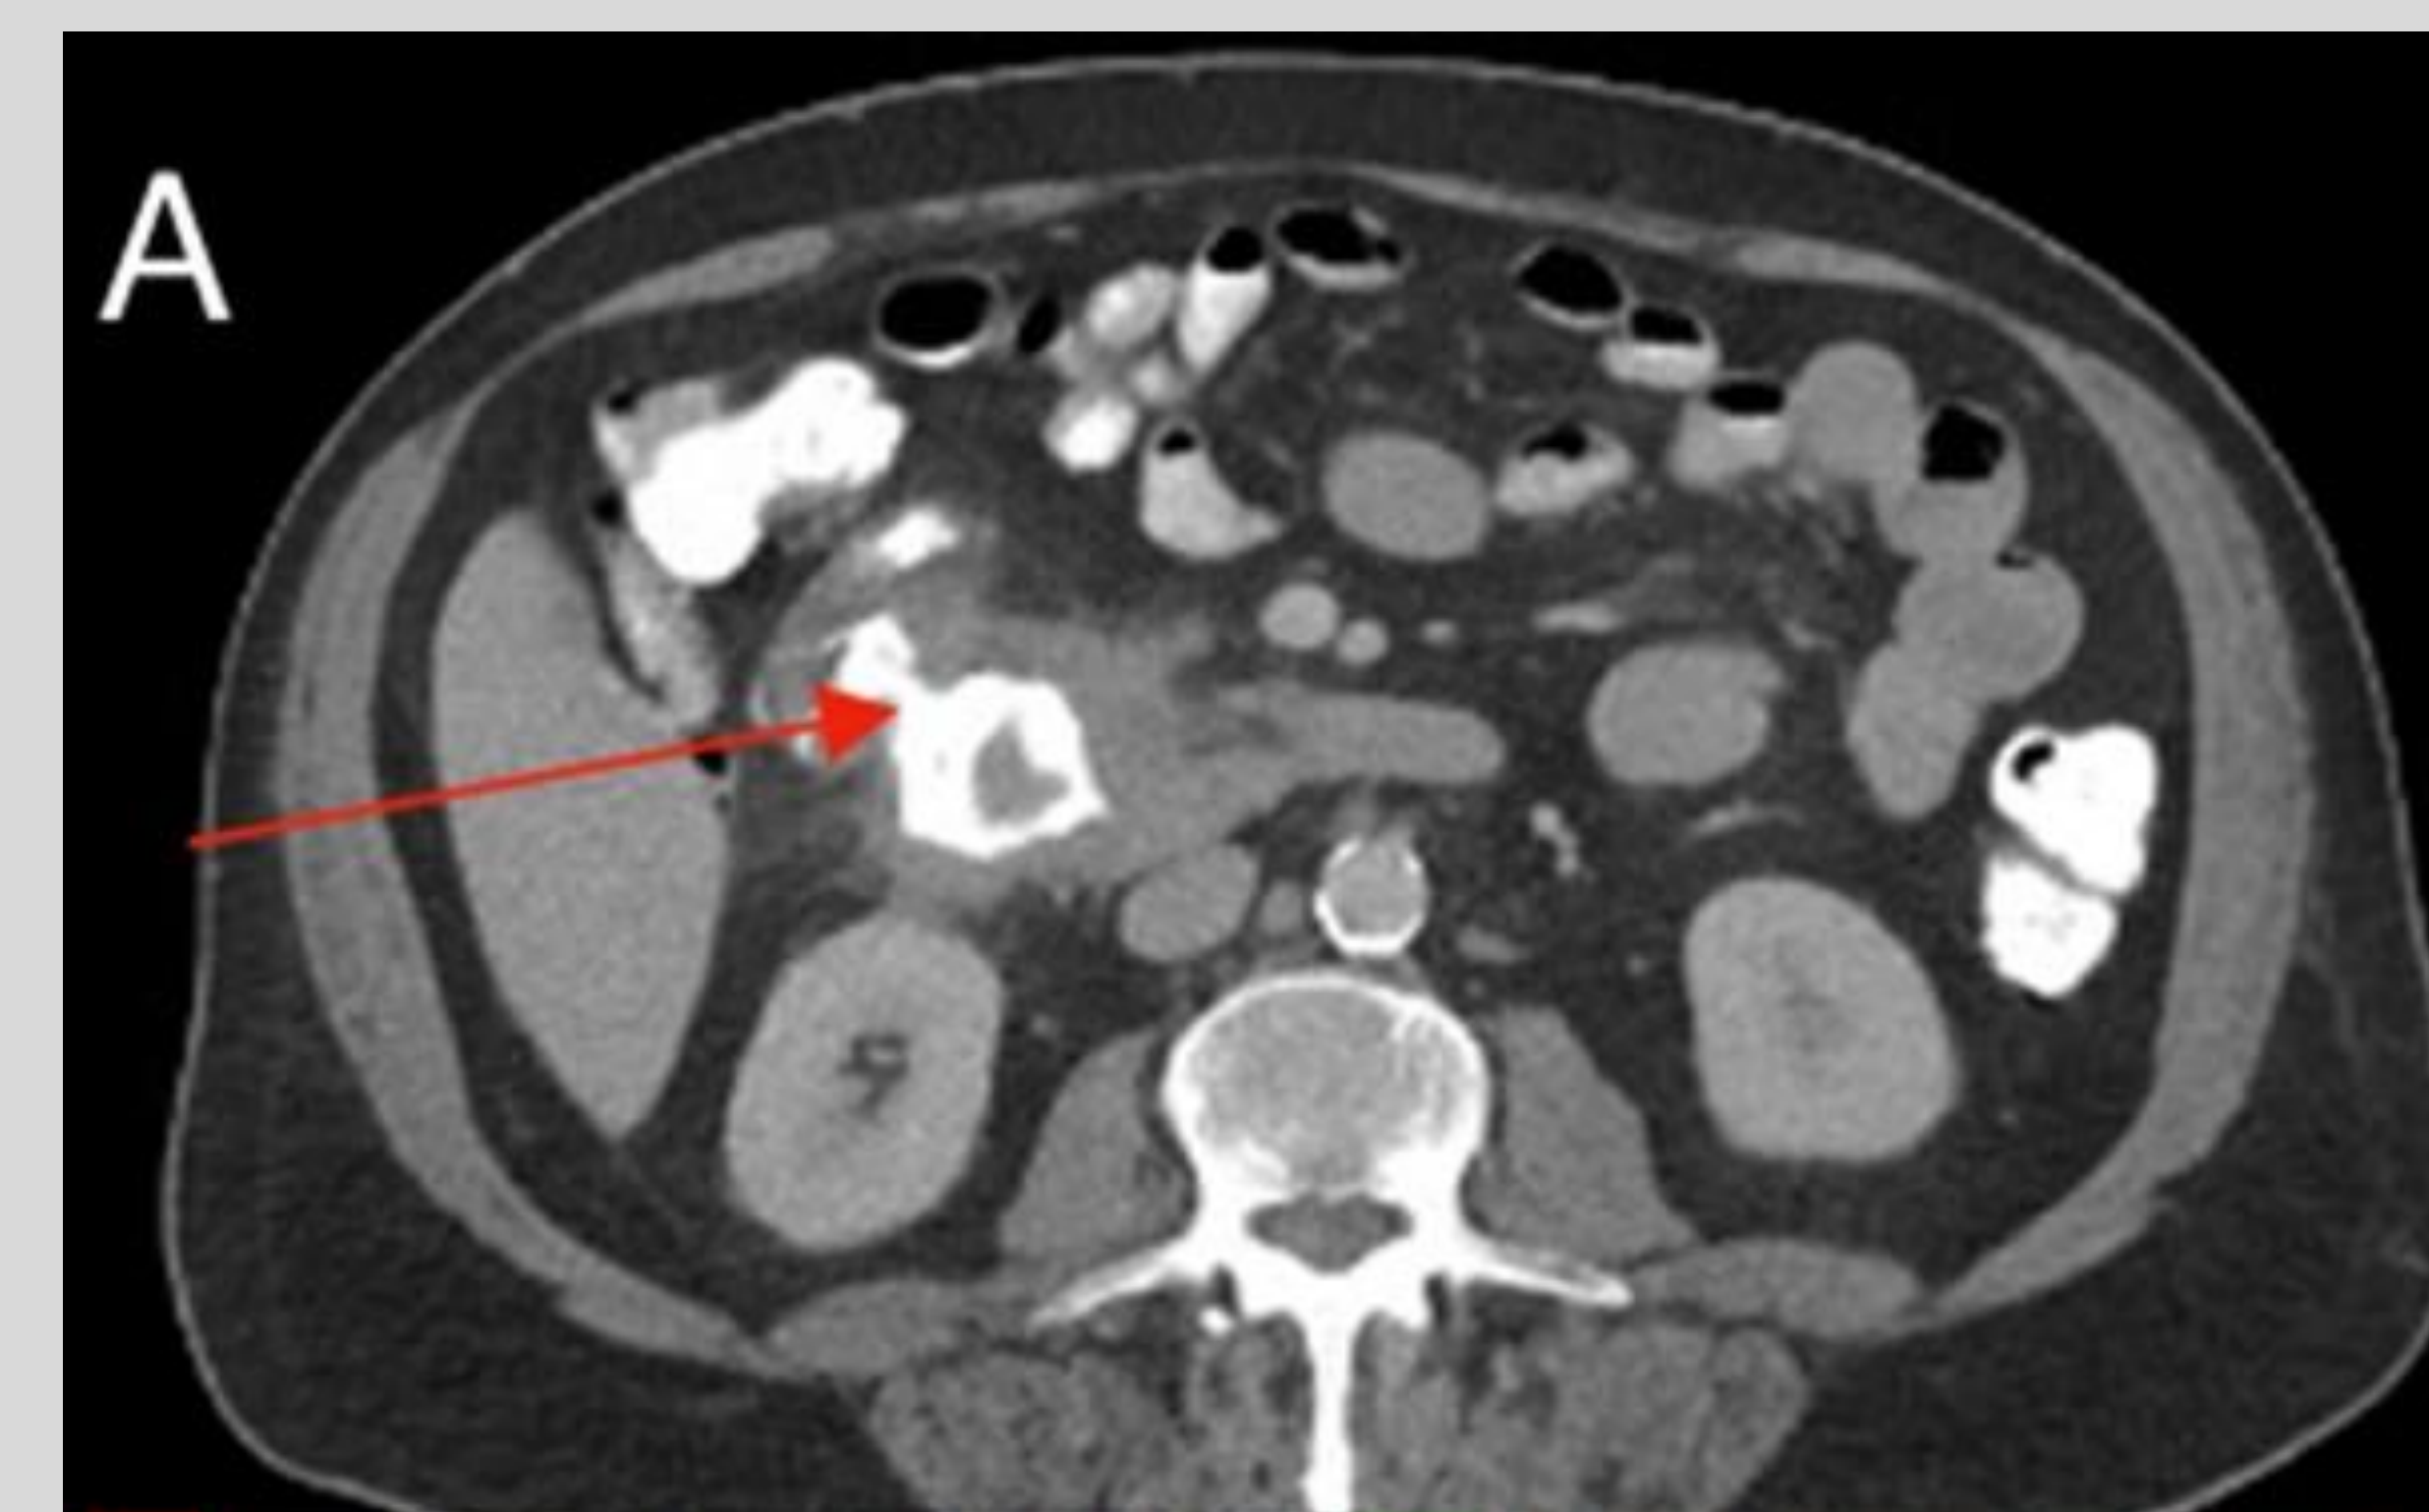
CT Abdomen with contrast showing colo-duodenal fistula (red arrow)
